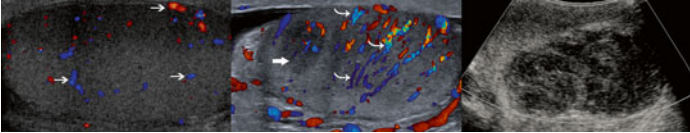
Sagittal Doppler US images. Normal testicle has homogenous echotexture and scattered vascularity (*white arrows*). By contrast, testicular lymphoma presents as an ill-defined, hypoechoic focus (*large white arrow*) with significant hypervascularity (*curved white arrows*). Scrotal hematoma can also appear irregular and heterogeneous, but should not demonstrate internal vascularity.
